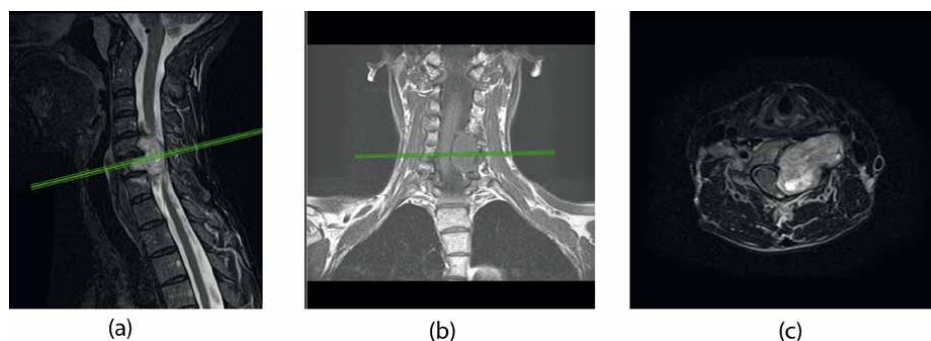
Contrast-enhanced MRI of the cervical spine of a patient with an intra-extradural dumbbell tumor that compresses the spinal cord and extends extravertebral, adjacent to the vertebral and carotid arteries. (a) Sagittal view (T2W + contrast enhancement); (b) coronal view (T1W) and (c) axial view (T2W + contrast enhancement).
